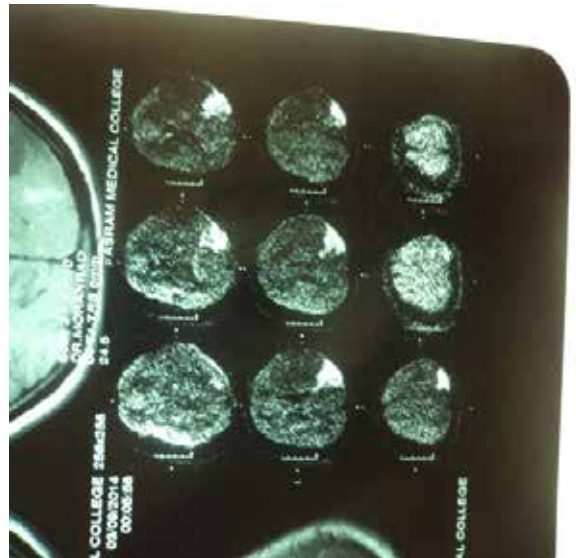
Diffusion images in MRI of the patient
